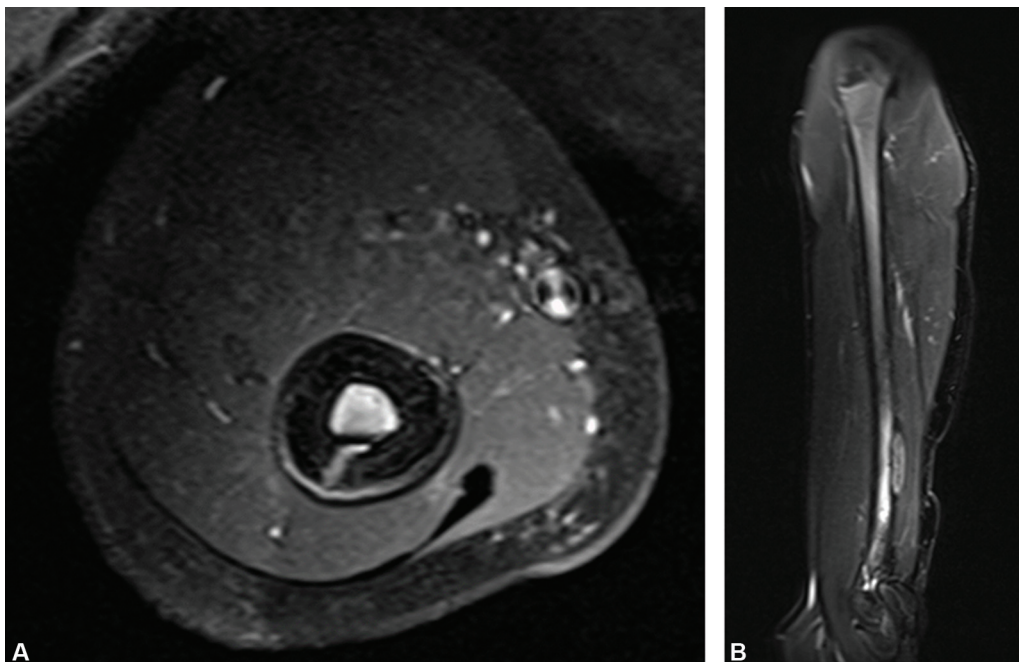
(A) Axial STIR magnetic resonance imaging revealing longitudinal fracture through the posterior cortex, which is thickened; endosteal and periosteal edema are also noticed. (B) Sagittal STIR MR image showing cortical thickening and bone marrow edema in distal humeral diaphysis.
